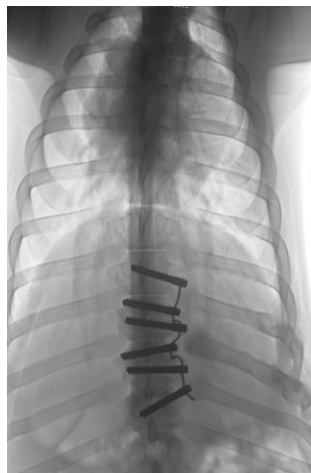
Post-operative dorsal-ventral radiograph of 3D tether after 30 days
